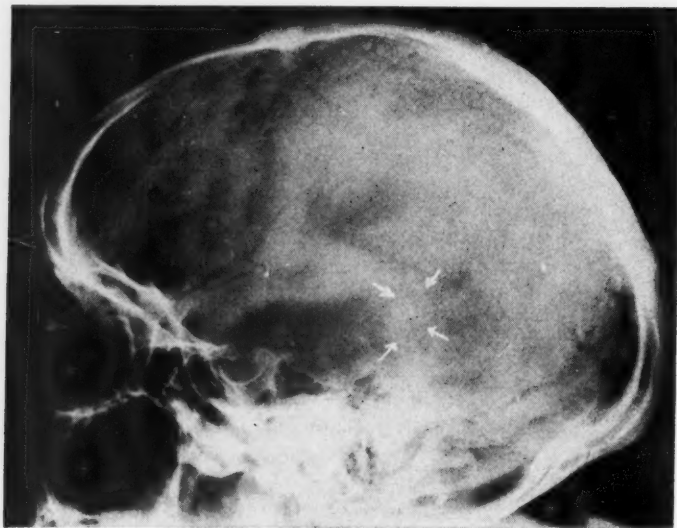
Case 3: Roentgenogram showing the faint pattern of lines of calcification indicating a vascular lesion. The calcified area represented only a small part of the total lesion, which weighed 26 Gm.
